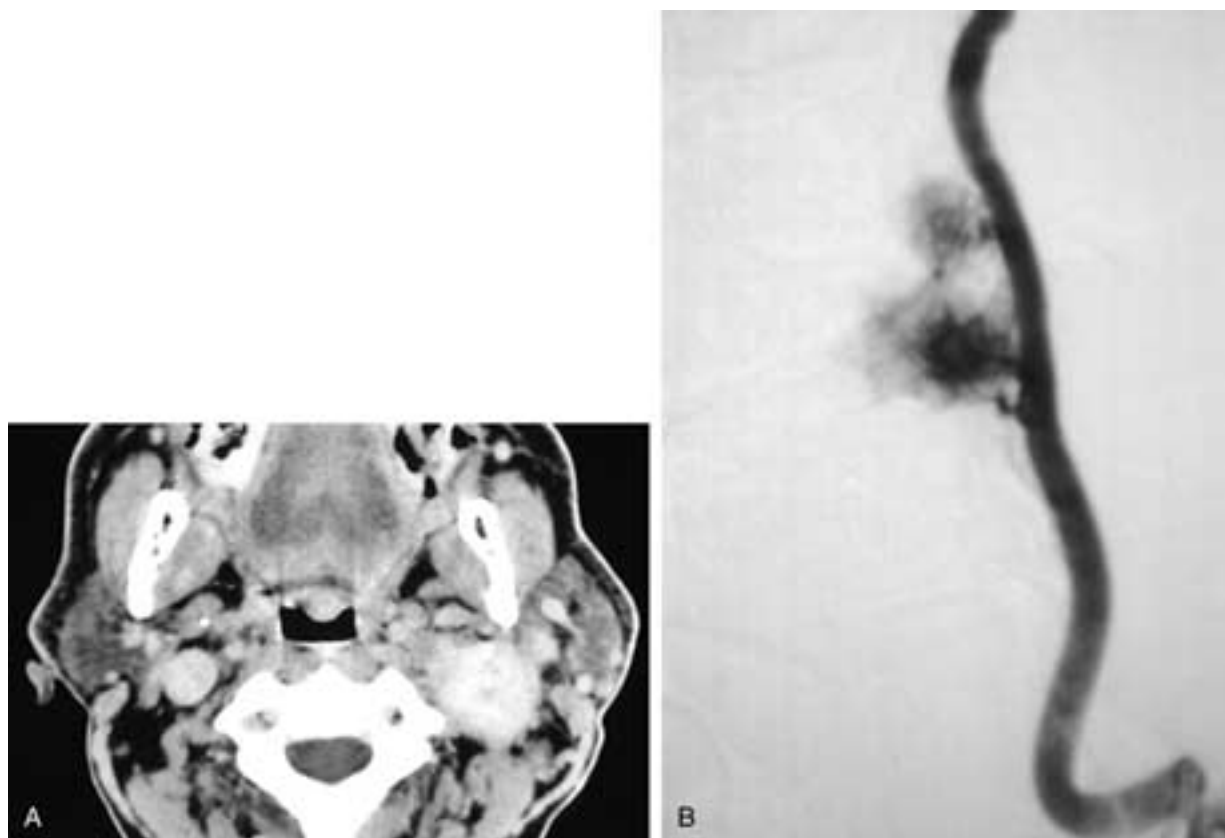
Axial contrast-enhanced CT scan (A) shows an enlarged, enhancing left level II node. In B, a lateral subtraction angiogram film, this mass is seen to actually be two adjacent hypervascular nodes. These were squamous cell carcinoma nodes.
